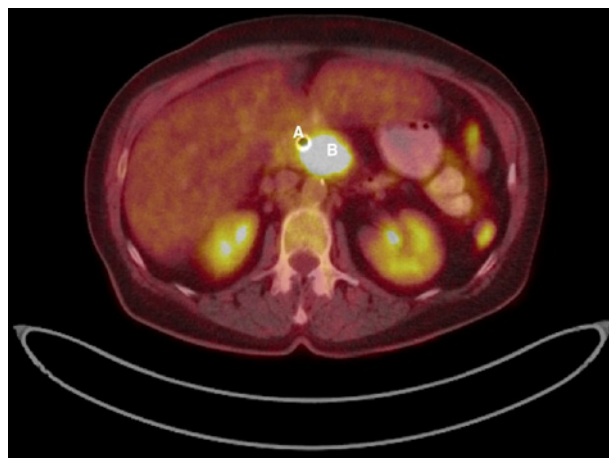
PET/CT scan. Stented common bile duct (A). FDG-avid pancreatic head mass (B). FDG, fluorodeoxyglucose.
